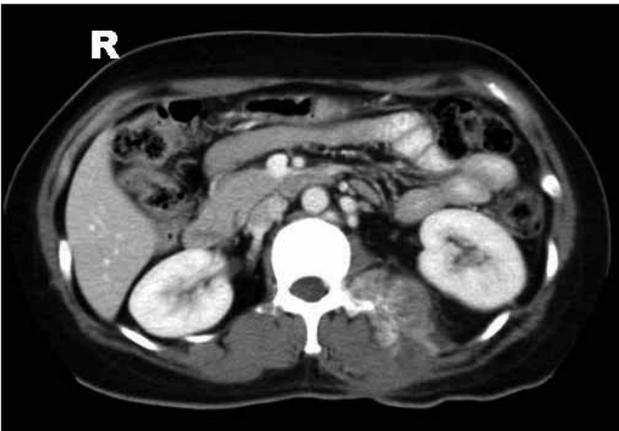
Post-excision contrasted abdominal computed tomography showing markedly enhanced lobulated residual tumour which has remained stable for 2 years.
